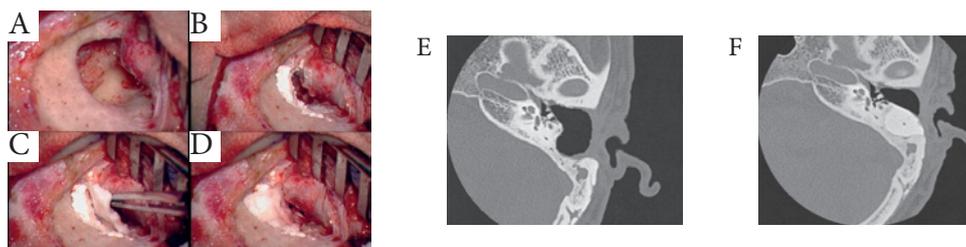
Intraoperative images of a CWD mastoidectomy bowl (A), gradually being reconstructed with calcium phosphate paste (B,C,D). E – preoperative CT scan showing CWD bowl. F – postoperative CT scan showing paste reconstruction. (From: Kakigi *et al.*¹¹)
